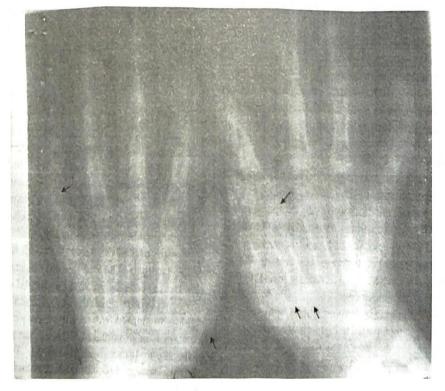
Anteroposterior radiograph of the hands showing short first metacarpals, clinodactyly and short middle phalanges of the little fingers. Noted also are synstoses of the bases of the left first and second metacarpals. The 2nd to the 5th metacarpals have epiphyses at both the proximal and distal ends instead of only at the distal ends
